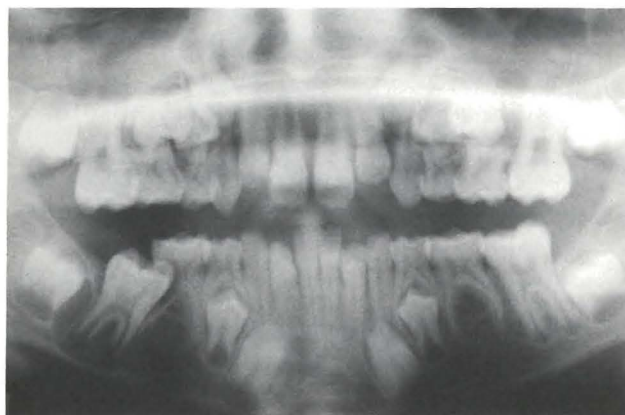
Panoramic radiograph (12/87) showing: (1) ectopic eruption of the lower left first permanent molar; (2) congenitally missing lower left and right second premolars; and (3) radiolucent area distal and inferior to the lower left first permanent molar.
